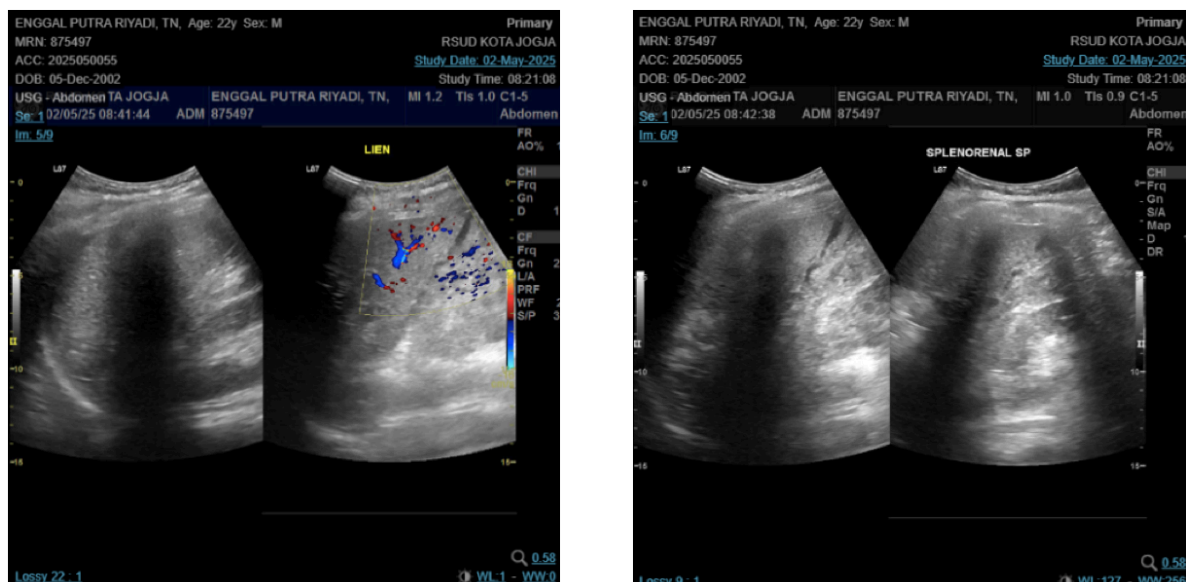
Abdominal ultrasound of Lien, splenomegaly with laceration with subcapsular hematome leading to renal sinistra hematome.
